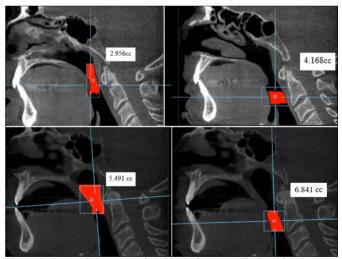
Pre and postoperative CBCT after mandibular advancement device application.
